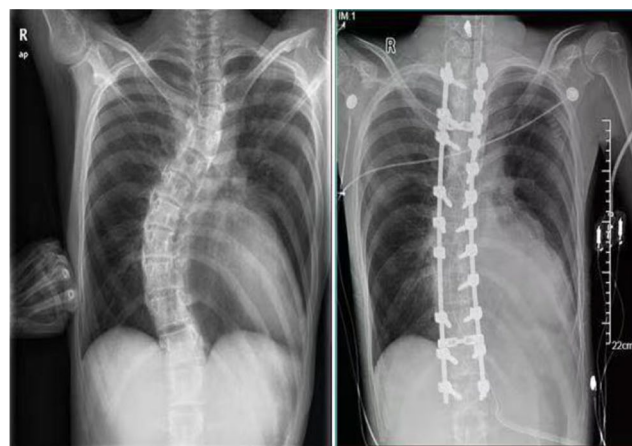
Pre and post-operative anteroposterior radiographs of the whole spine, Cobb angle 52°
